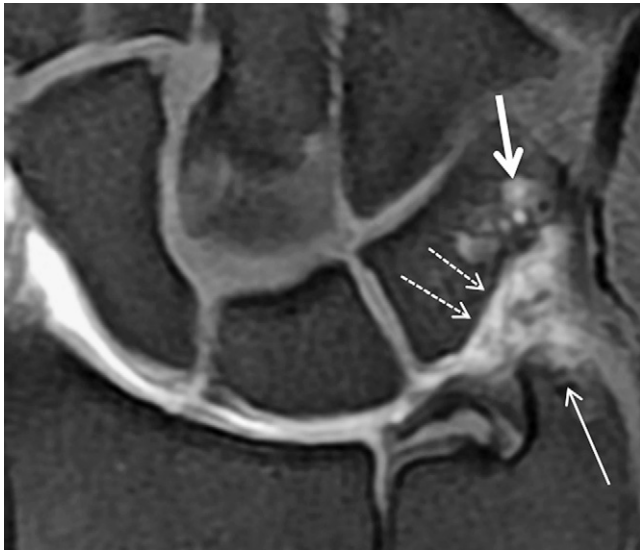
Ulnar styloid impaction. Coronal T1-weighted fat-saturated magnetic resonance arthrographic image, demonstrating a long ulnar styloid process (thin white arrow), triquetral chondromalacia (dotted white arrows), and cyst formation in the triquetrum (thick white arrow).
